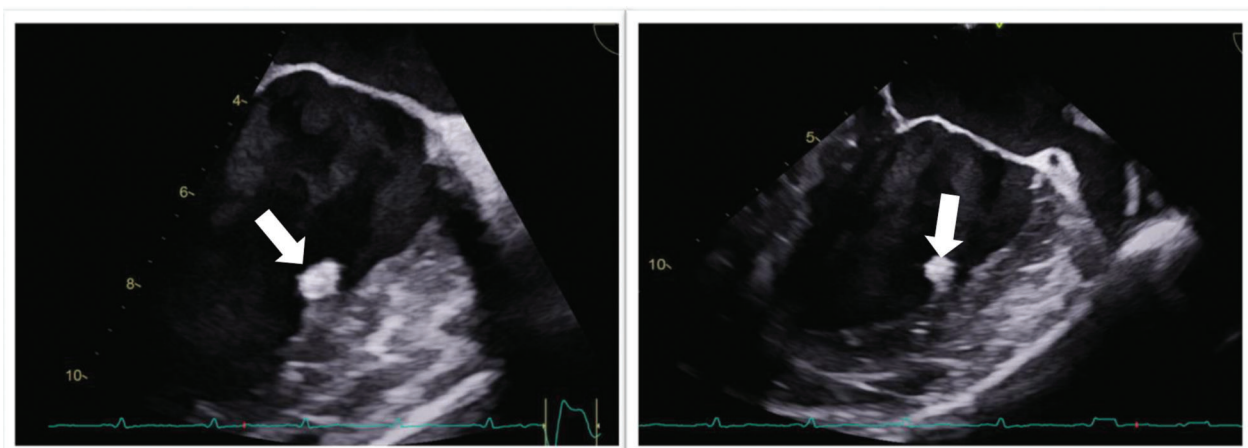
Zoomed four chambers transesophageal echocardiology showing echogenic mobile mass attached to papillary muscle (fibroelastoma).
